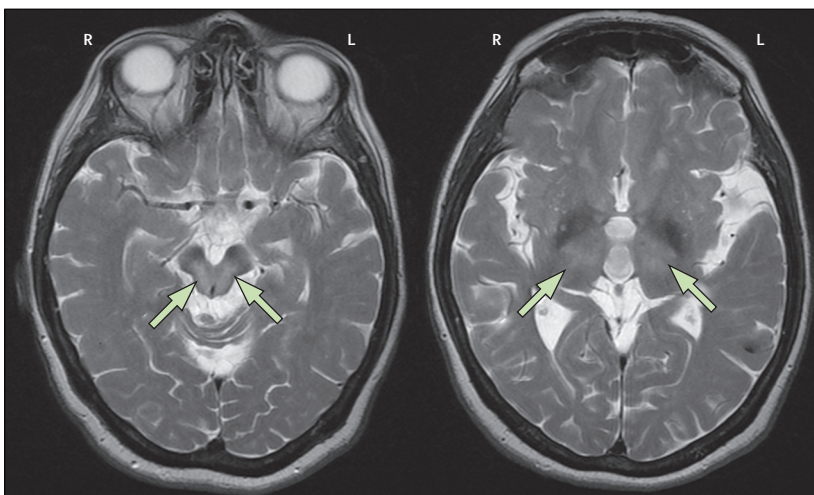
Representative T2-weighted axial brain MRI scan showing symmetrical T2-weighted hyperintense lesions (solid green arrows) in the tectal midbrain on the left and in the ventromedial thalami and posterior limbs of the internal capsule on the right
